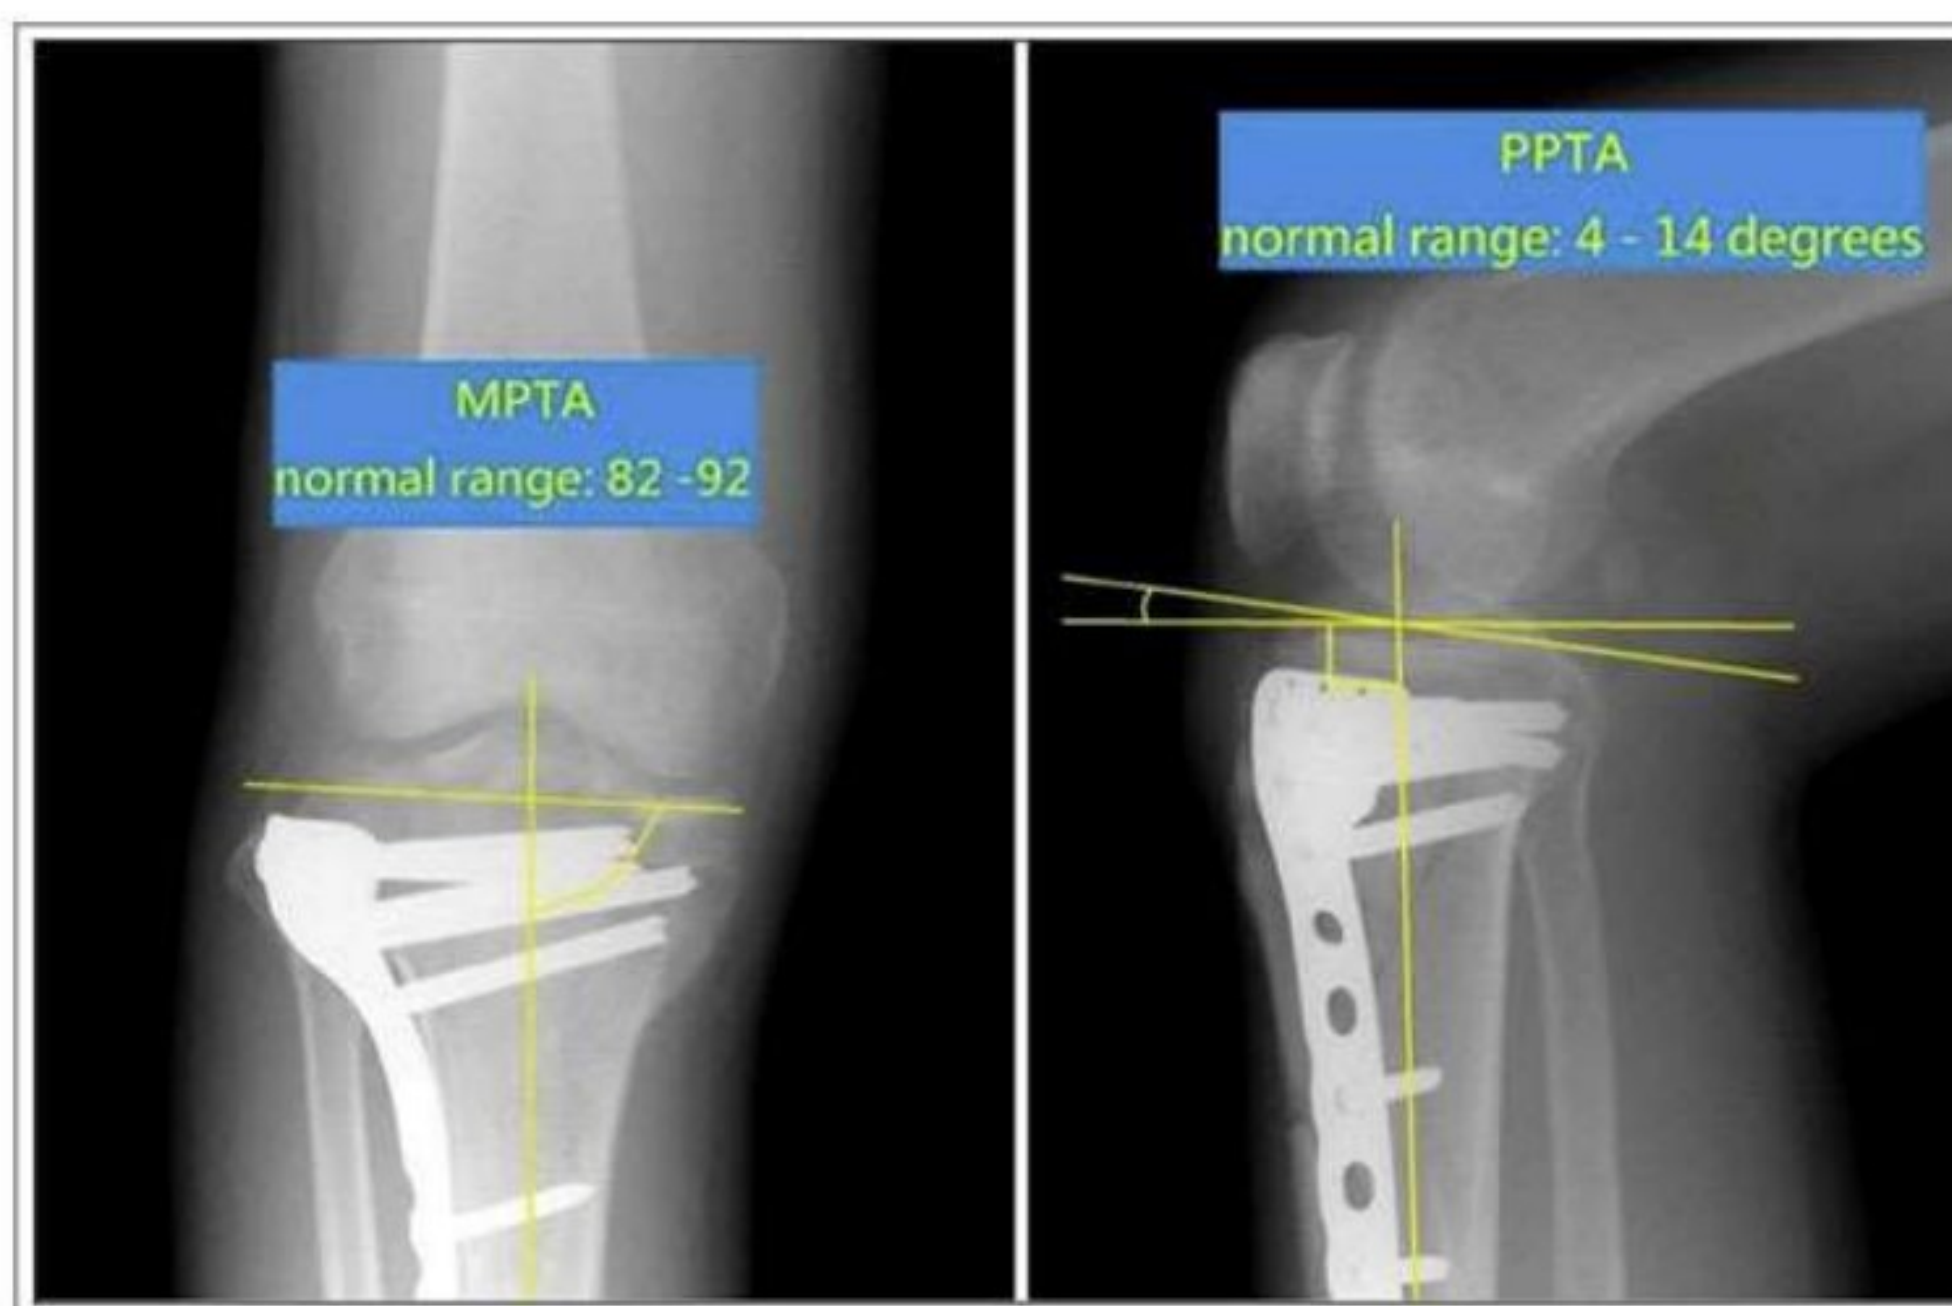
Radiographic measurement of MPTA and PPTA and normal reference range
